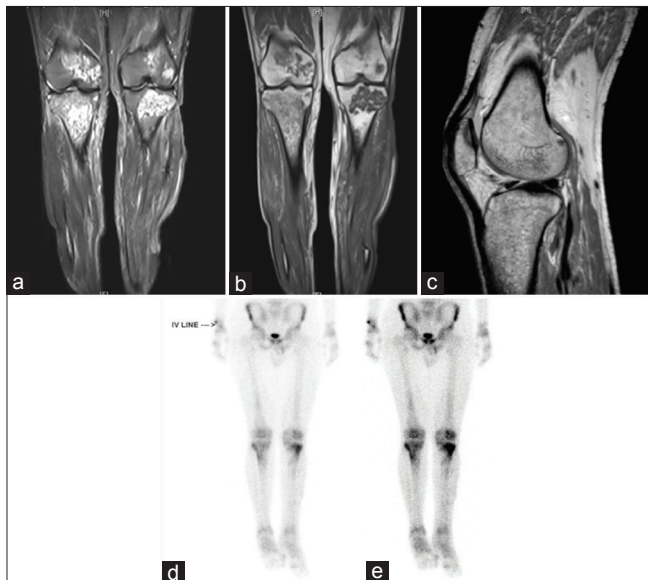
(a) T2W coronal image of both knees showing multifocal osteomyelitis noted as hyperintense lesions involving metadiaphyseal region of the femur and tibia bilaterally. (b) T1w coronal image showing hypointense lesions in the corresponding areas. (c) Proton density weighted MRI sequence image showing intact capsule with sparing of the joint. (d and e) triphase scintigraphy – increased tracer activity noted in both knees in the vascular, tissue and delayed phases after intravenous administration of Tc99m
